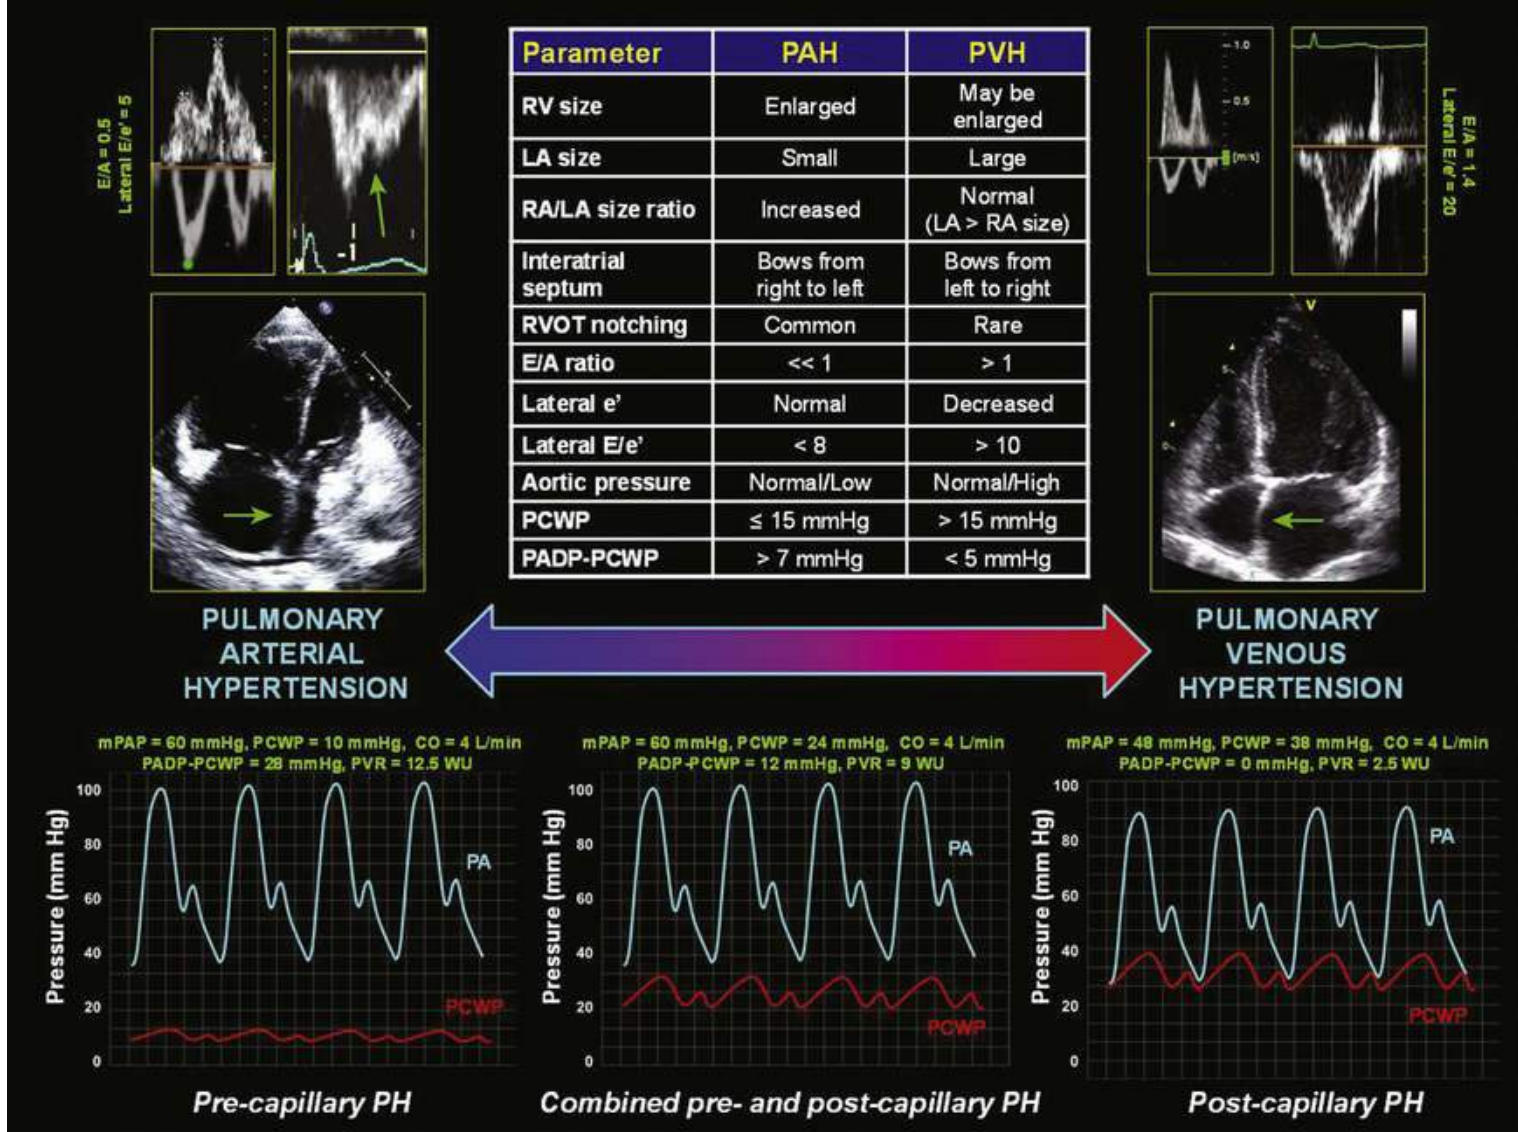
Pulmonary arterial hypertension versus pulmonary venous hypertension: echocardiographic and invasive hemodynamic differentiation. The left panel demonstrates prototypical echocardiographic and invasive hemodynamic findings from a patient with PAH. The right atrium and right ventricle are severely enlarged, and the left ventricle and left atrium are small and underfilled. The interatrial septum bows from right to left. On mitral inflow, the E/A ratio is less than 1 because of underfilling of the left atrium and decreased compliance of the left ventricle due to extrinsic compression from the enlarged right ventricle. The lateral e' velocity and lateral E/e' ratio are normal (<8), suggesting normal left ventricular relaxation and filling pressures. There is notching in the right ventricular outflow tract profile on pulse-wave Doppler imaging due to increased PA stiffness. PCWP is normal and the PADP-PCWP gradient is severely increased. The right panel demonstrates prototypical echocardiographic and invasive hemodynamic findings from a patient with pulmonary venous hypertension. The left atrium is enlarged and the interatrial septum bows from left to right. On mitral inflow, the E/A ratio is more than 1, lateral e' velocity is reduced, and lateral E/e' ratio is increased, suggestive of grade 2 diastolic dysfunction with impaired left ventricular relaxation and elevated left ventricular filling pressures. There is no notching in the right ventricular outflow tract profile. PCWP is elevated and there is no gradient between the PADP and PCWP. Note that although the right ventricle in the right panel is not enlarged, right ventricular enlargement and dysfunction can be present in patients with isolated pulmonary venous hypertension. The middle panel includes a table listing parameters for echocardiography and invasive hemodynamic testing that are helpful for differentiating PAH from pulmonary venous hypertension. The lower middle panel demonstrates invasive hemodynamic findings in a patient with combined precapillary and postcapillary PH (elevated PCWP and PADP-PCWP gradient). It should be noted that the most challenging patients are in this middle zone (combined precapillary and postcapillary PH), with echocardiographic findings that lie in the middle of the prototypical examples of PAH and pulmonary venous hypertension shown here. In these patients, careful evaluation of the echocardiogram and invasive hemodynamics will be necessary for an accurate diagnosis. CO, cardiac output; E/A, ratio of early to late (atrial) mitral inflow velocities; E/e', ratio of early mitral inflow velocity to early diastolic mitral annular tissue velocity; LA, left atrial; mPAP, mean pulmonary arterial pressure; PADP, pulmonary artery diastolic pressure; PAH, pulmonary arterial hypertension; PCWP, pulmonary capillary wedge pressure; PH, pulmonary hypertension; PVH, pulmonary
